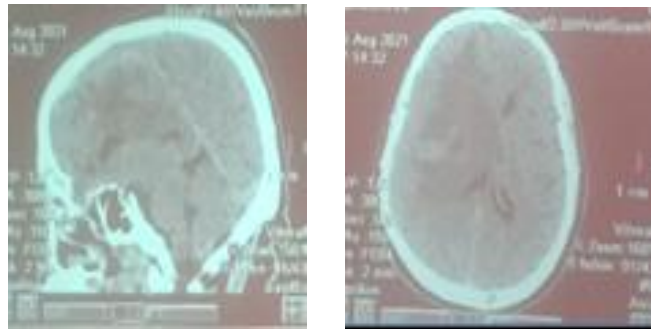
CT scan showing the tumor.
